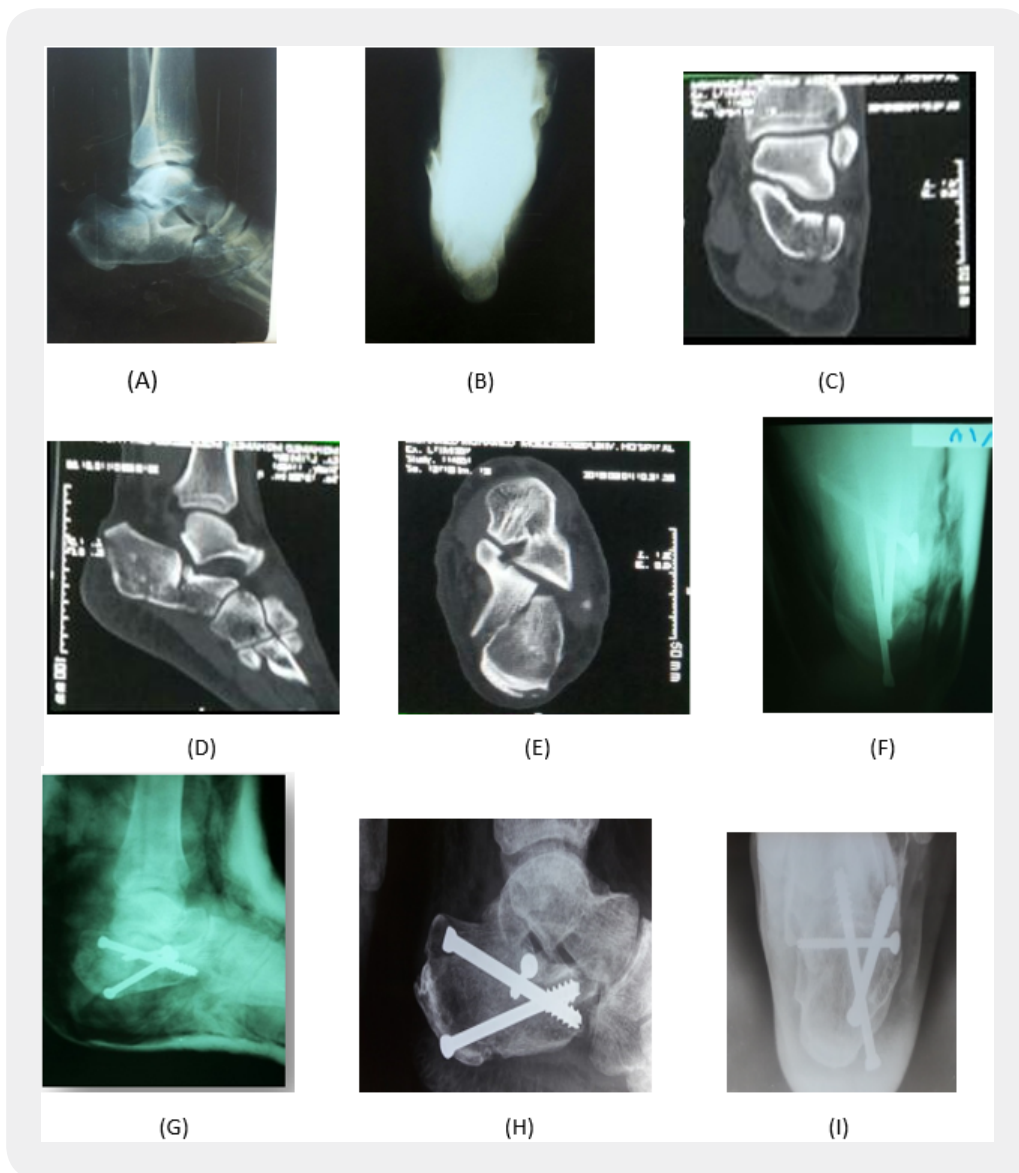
45 years male patient. (A, B) pre-operative X-ray, (C, D, E) pre-operative CT (F,G) immediate post-operative X-ray, (H,I) follow up X-ray after six months with good result
